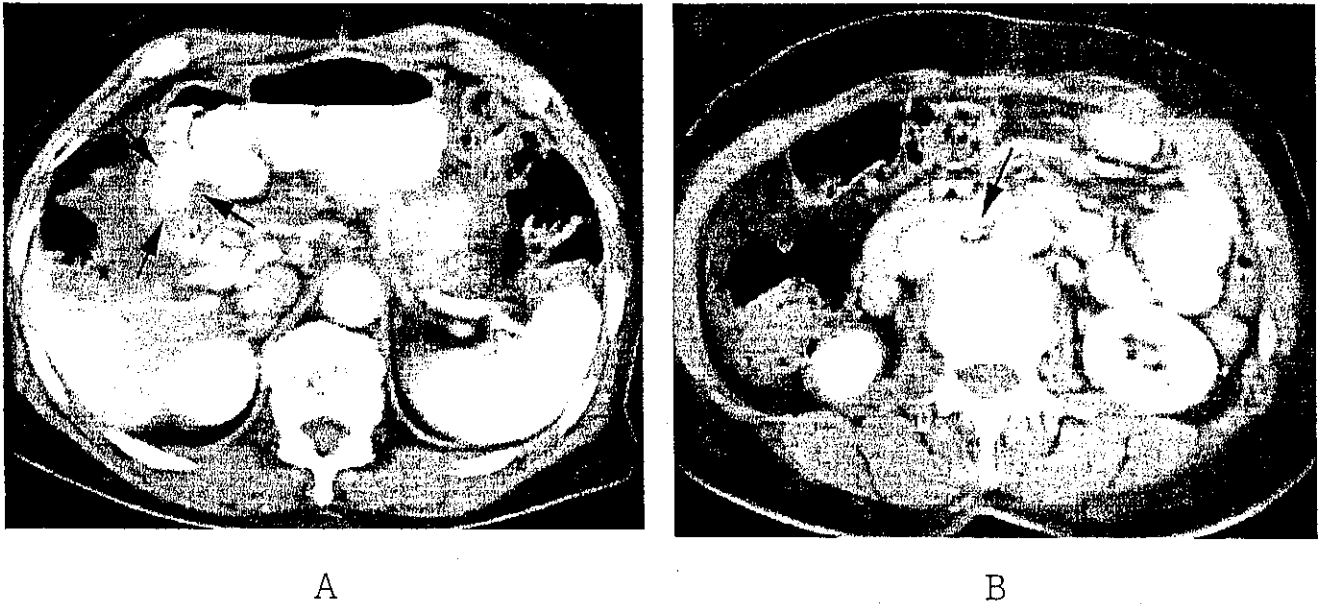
An abdominal computed tomography (CT) scan after 6 courses of irinotecan (CPT-11) and mitomycin C (MMC) revealed the disappearance of the tumor in the antrum (black arrows) (A) and lymph node swelling at #16 (black arrow) (B).
